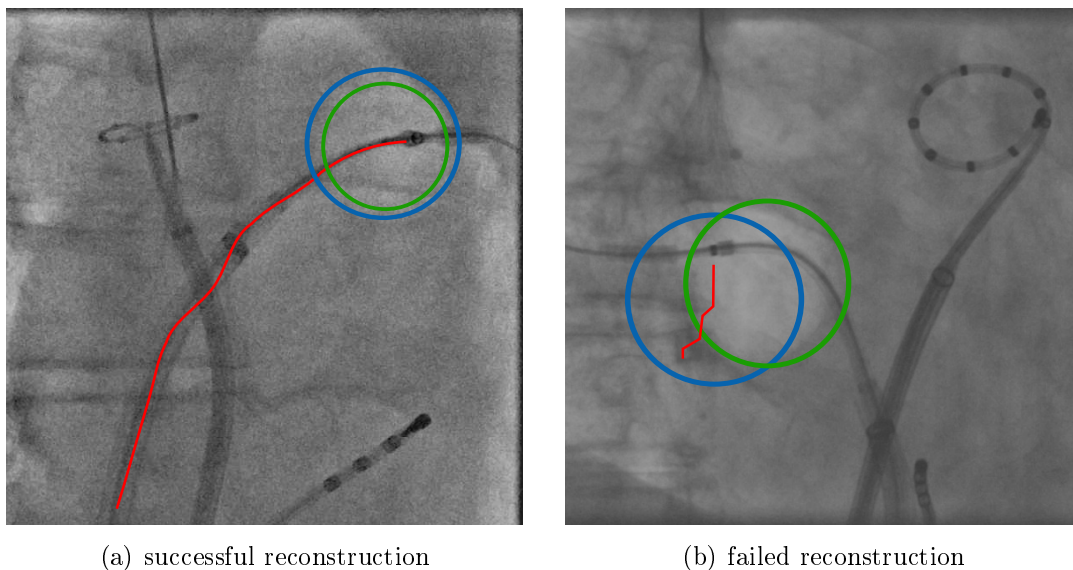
Example reconstruction results. The forward projected boundary of the 3-D ground-truth cryoballoon obtained using [Klei 11] is shown in green, the result of the 0-click model based reconstruction is shown in blue. The reconstructed shaft is shown in red. In (a), the reconstruction of the cryoballoon was successful. Although the reconstruction of the shaft is slightly inaccurate, the balloon reconstruction is unaffected as the shaft part close to the balloon is reconstructed correctly. Note that the diameter of the green balloon reconstruction is smaller than the diameter specified by the manufacturer. The cryoballoon boundary’s visibility depends on a change in X-ray density. For this density difference to become apparent, the X-ray path through the different material needs to be sufficiently long. At the sphere borders, the path length through the balloon is short. As a consequence, the balloon may appear smaller in X-ray projections than its actual size. Therefore, the method of Kleinoeder et al. [Klei 11] tends to underestimate the size of the cryoballoon. In (b) a failed reconstruction is displayed. Here, the the shaft (red) was not detected correctly.
